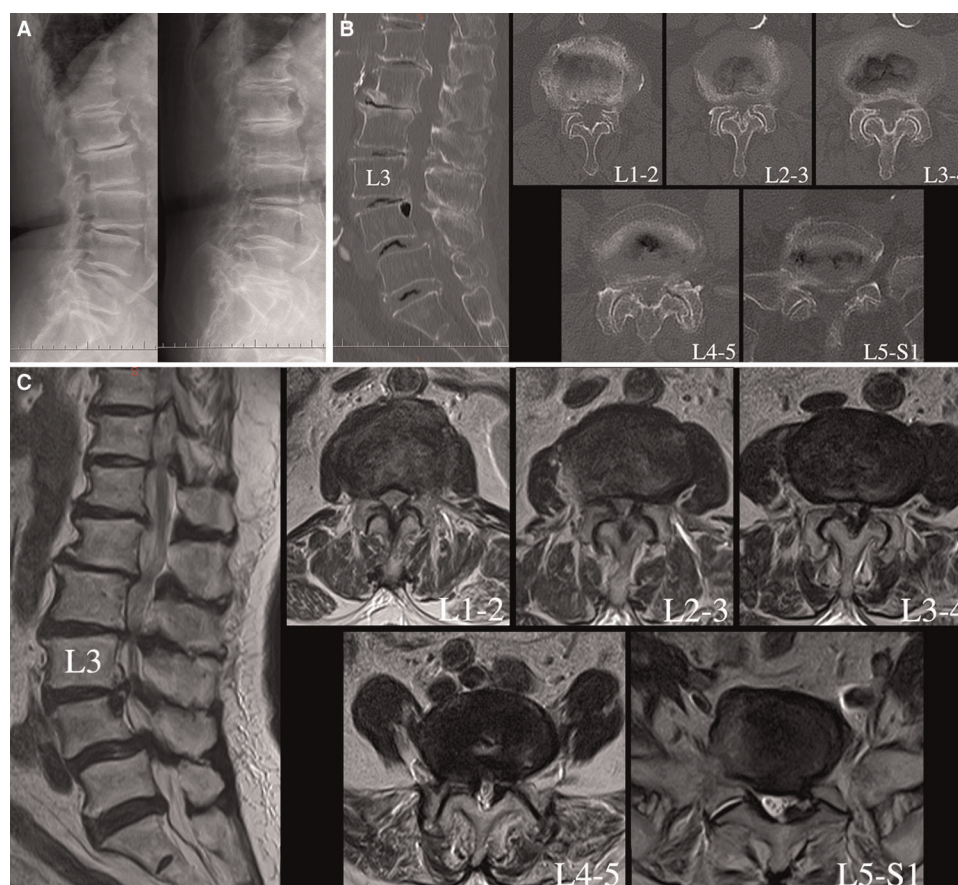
Flexion and extension lateral lumbar X-ray radiograph demonstrating relative dynamic stability at all lumbar segments (A). Lumbar CT showing hyperplasia and cohesion of the facet joints, ossification of the ligamentum flavum and multilevel stenosis of the lateral recesses and central canals (B). Sagittal and axial T2-weighted lumbar MRI revealing serious central canal stenosis from L1-2 to L4-5, lumbar disc herniation and left lateral recess stenosis at L5-S1 (C).
